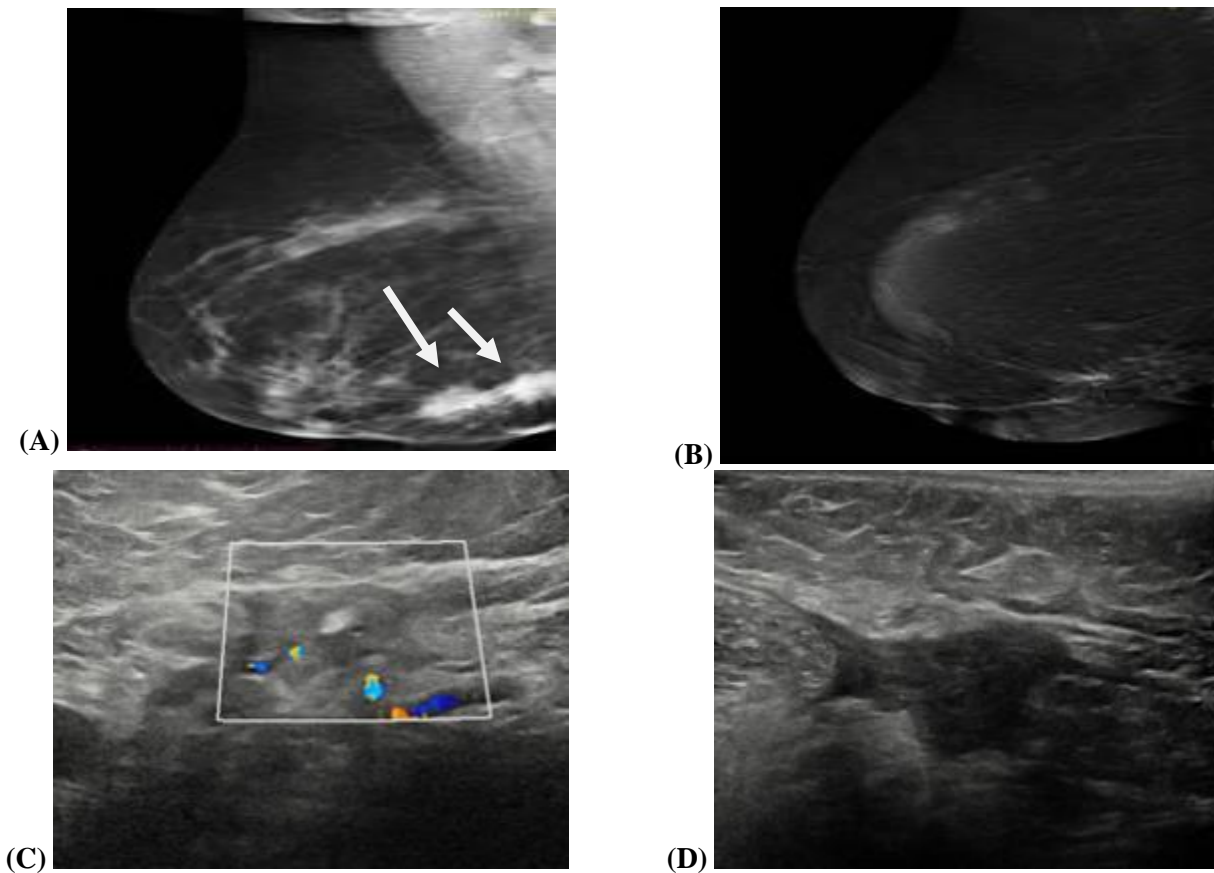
A 73-years-old female underwent right conservative breast surgery on follow-up. (A): DM: (MLO) of the right breast revealed two suspicious irregular lesions on the right operative bed. (C-D): ultrasound revealed two suspicious lesions at operative bed with internal vascularity (BI-RADS 4), (B): MLO view of CEDM of right breast revealed no enhancement of these lesions suggestive of post-operative scar tissue and were categorized as BI-RADS 2. Pathology result was fibrous scar tissue.
